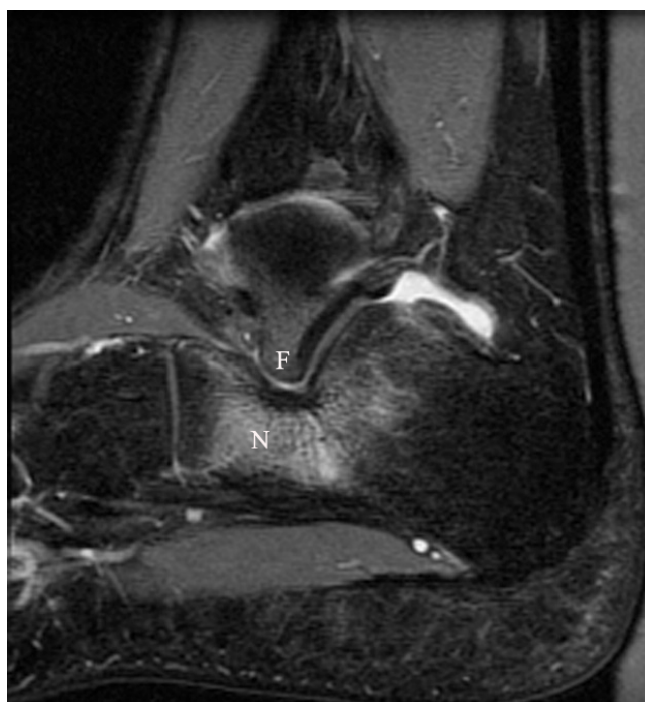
MR imaging demonstrating abutting bone marrow edema between the accessory facet (F) and the calcaneal neck (N).
